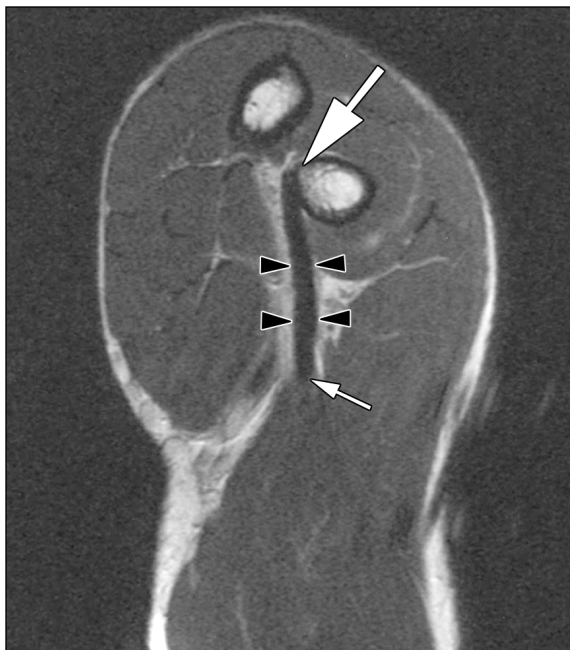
32-year-old healthy male volunteer. Proton density-weighted MR image (TR/TE, 3,000/34) of normal flexed abducted supinated view of distal biceps brachii tendon shows straight course of tendon from musculotendinous junction to insertion and homogeneous low signal of tendon. Large arrow = radial tuberosity, arrowheads = distal biceps tendon, small arrow = musculotendinous junction.
